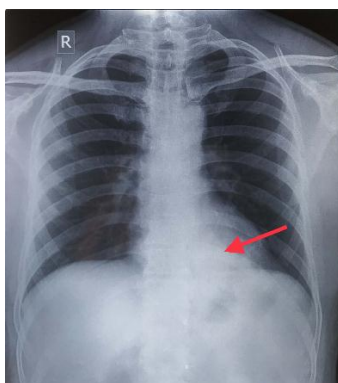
Chest radiograph showing a triangular opacity in left lower zone overlapping the cardiac shadow.
